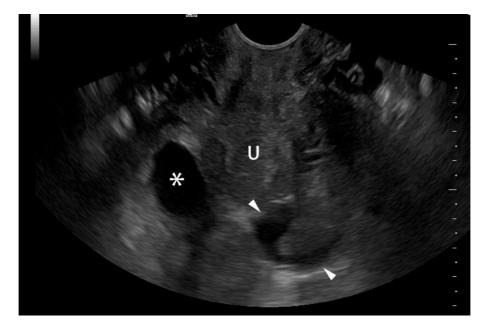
Transvaginal ultrasonogram from a gorilla with failure to conceive. U = uterus, * = ovarian follicle on the right ovary, arrowheads indicate a complex cyst in the left ovary
